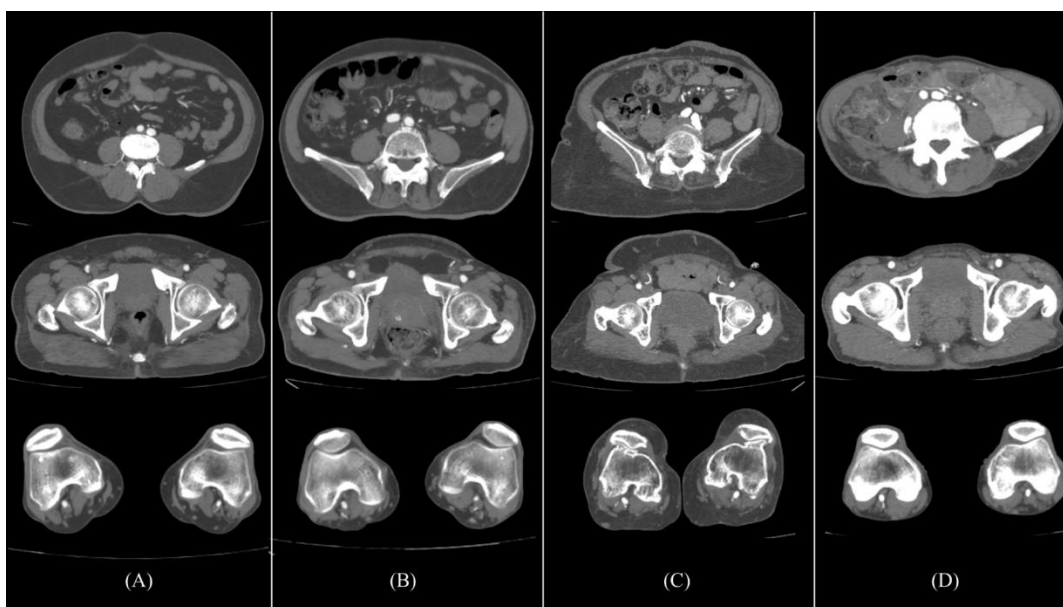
An axial image of a lower limb vessels. CT images of a (A) 55 years old male patients scanned with protocol A, (B) 72 years old male patients scanned with protocol B, (C) 70 years old female patient scanned with protocol C, and (D) 63 years old male patient scanned with protocol D.
